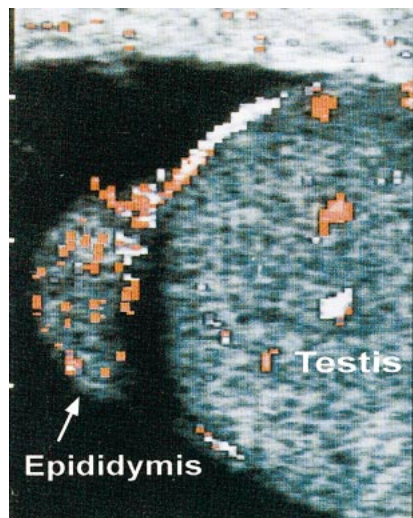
Epididymitis in longitudinal color Doppler sonographic scan. Note the presence of increased blood flow (demonstrated as red pixels) in the caput epididymis.
